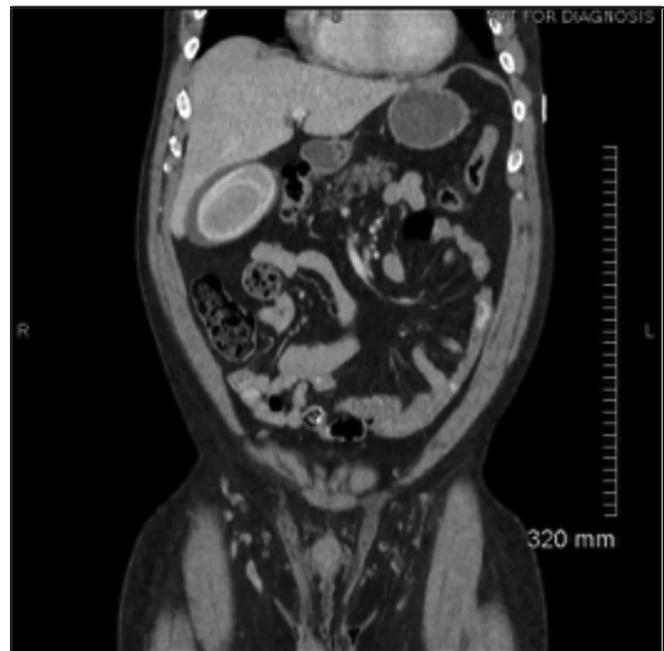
Abdominal CT Reveals an Enormous Gallstone
